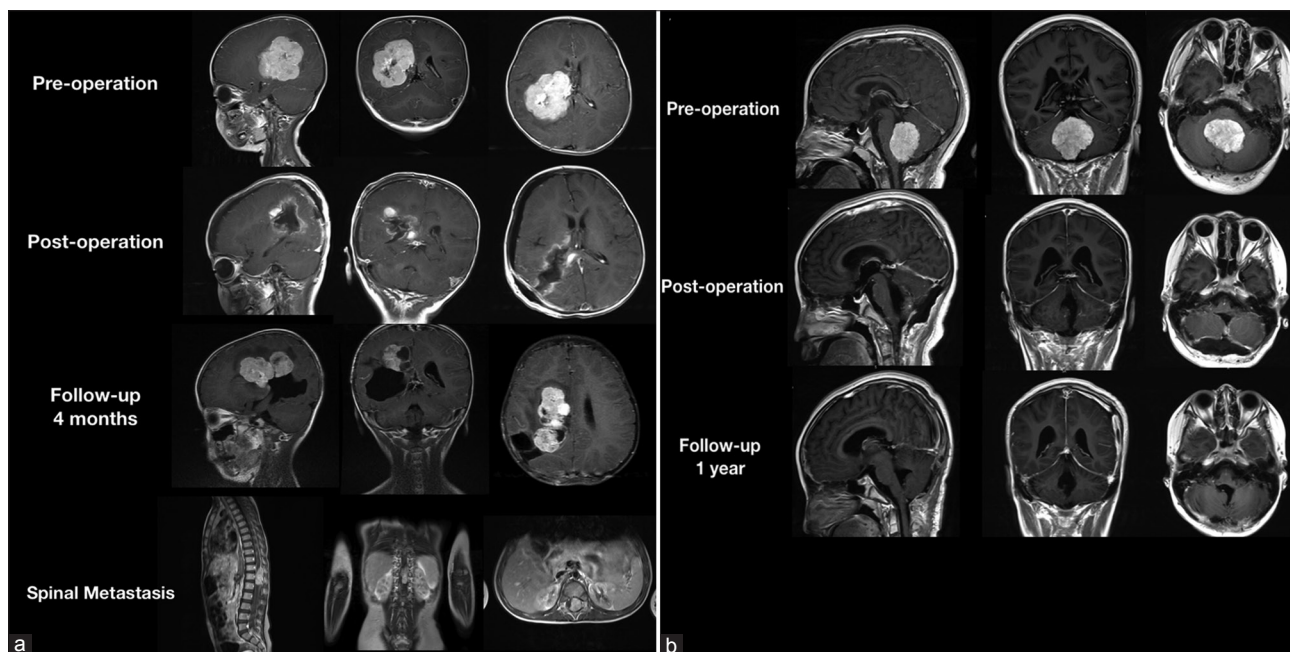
MR images of two pediatric patients with metastatic progression. (a) MR images of the 36-month-old boy diagnosed with CPC with metastatic spread after surgery. (b) MR images of the 60-month-old boy diagnosed with CPC in the fourth ventricle with metastasis to the spinal canal before surgery. MR: Magnetic resonance; CPC: Choroid plexus carcinoma.
